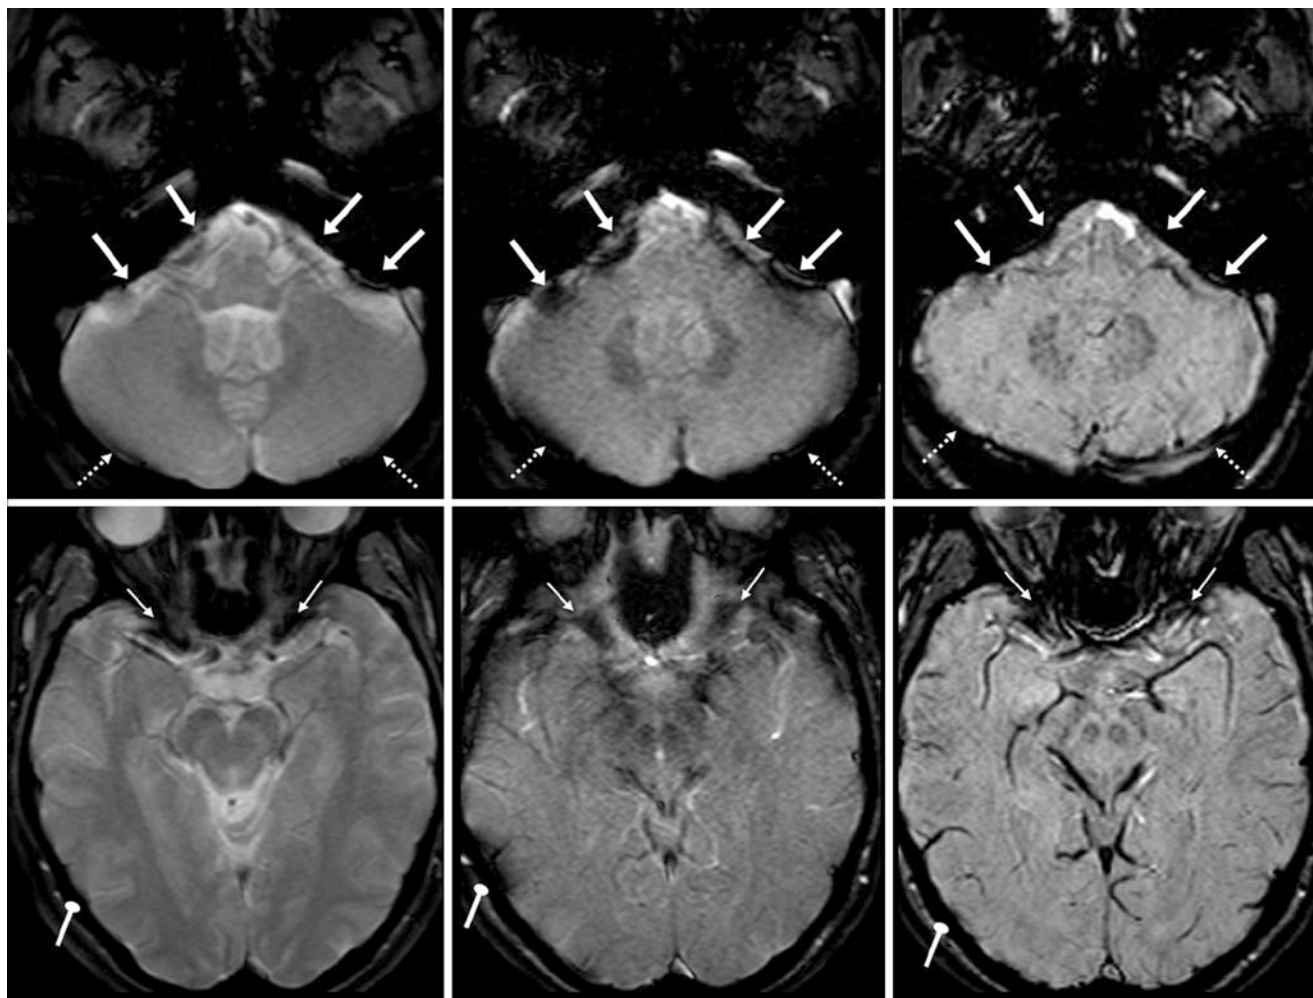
Air-bone interface artifact from several locations. A 37 year old with headaches underwent 1.5T MRI with three separate 2-mm-thickness sequences: routine GE T2*WI (*left column*), modified GE T2*WI (*middle column*, with flip angle, TR, and TE identical to the SWI sequence) and the true three-dimensional SWI acquisition (*right column*). The modified T2*WIs suffer the presence of greater artifacts from phase loss (T2* affect) but are more sensitive in detecting hemorrhage than standard GE T2*WIs. *Top row*: as expected, T2* effects are most noticeable on the modified GE T2*WI, being most
